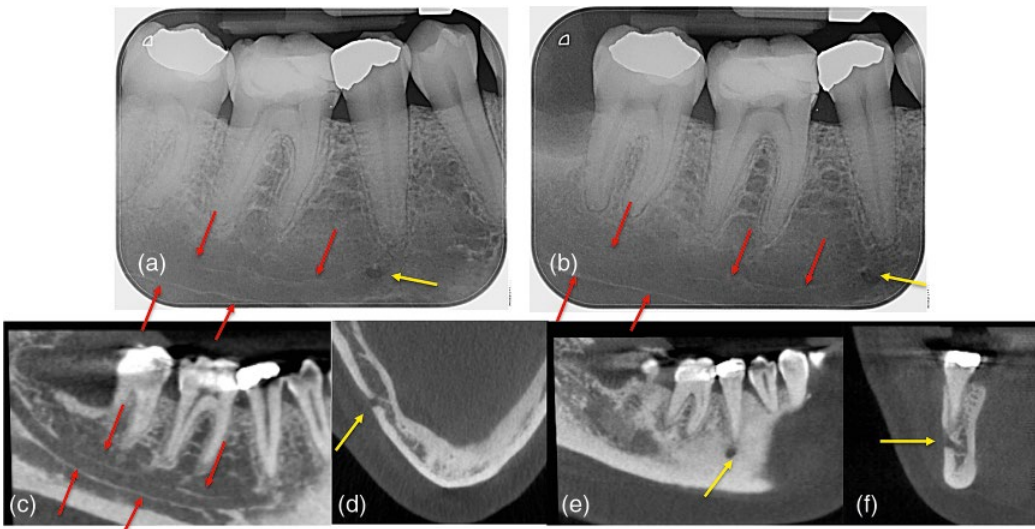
Mandibular anatomy. (a–b) Periapical radiographs of mandibular right molar and premolar teeth. The inferior dental nerve canal is represented by parallel, thin, radiopaque lines (red arrows) running in a mesio-distal direction, terminating mesially at the mental foramen, which appears as a well-defined, oval radiolucency (yellow arrow). (c) Sagittal CBCT view of the ID nerve cana. The true course and relationship of the canal can be appreciated and related to apices of the teeth. (d–f) Axial (d), Sagittal (e) and coronal (f) CBCT views demonstrating the position of the mental foramen (yellow arrows) in all planes.
